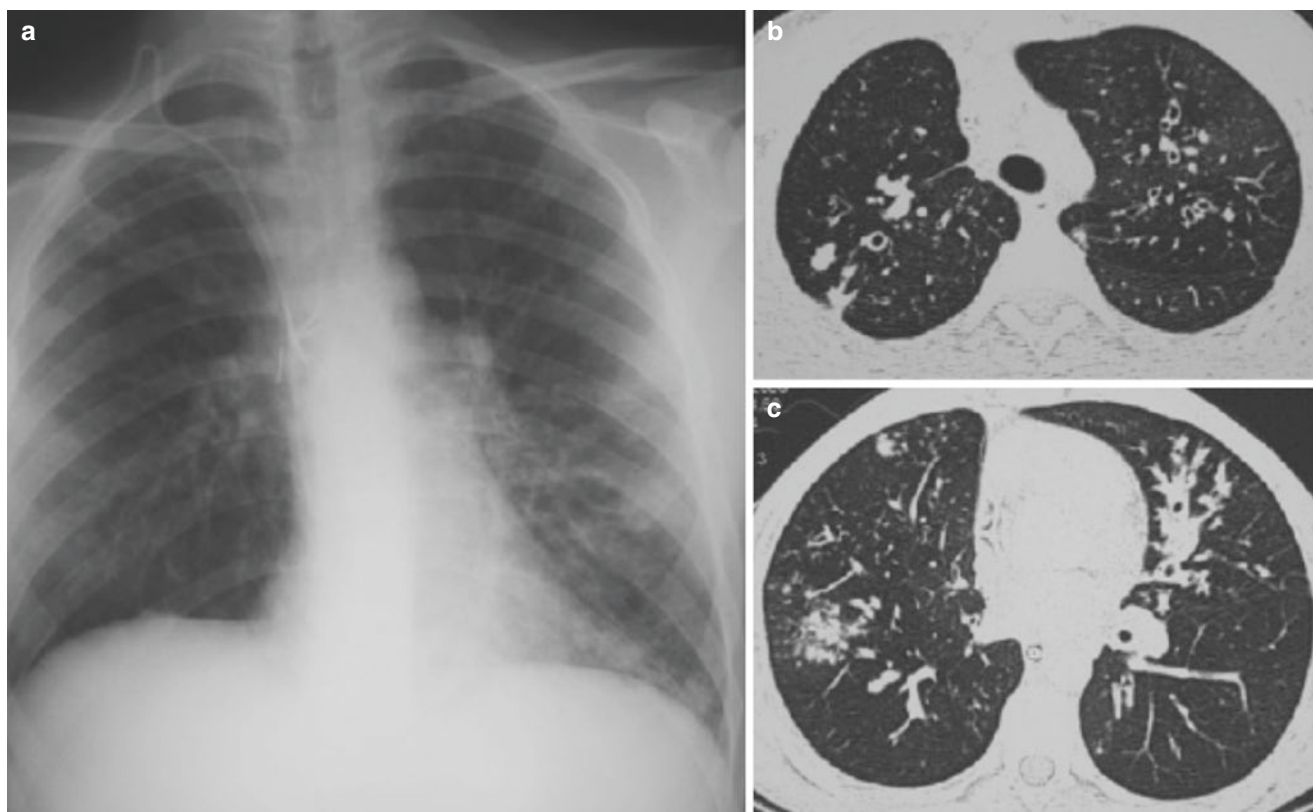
(a–c) Allergic bronchopulmonary aspergillosis occurs in children with asthma, as well as those with cystic fibrosis (frequently those with a known asthmatic component). A 16-year-old boy with allergic bronchopulmonary aspergillosis (ABPA) in the setting of CF. (a) Chest x-ray shows ill-defined patchy opacification in the left lower
